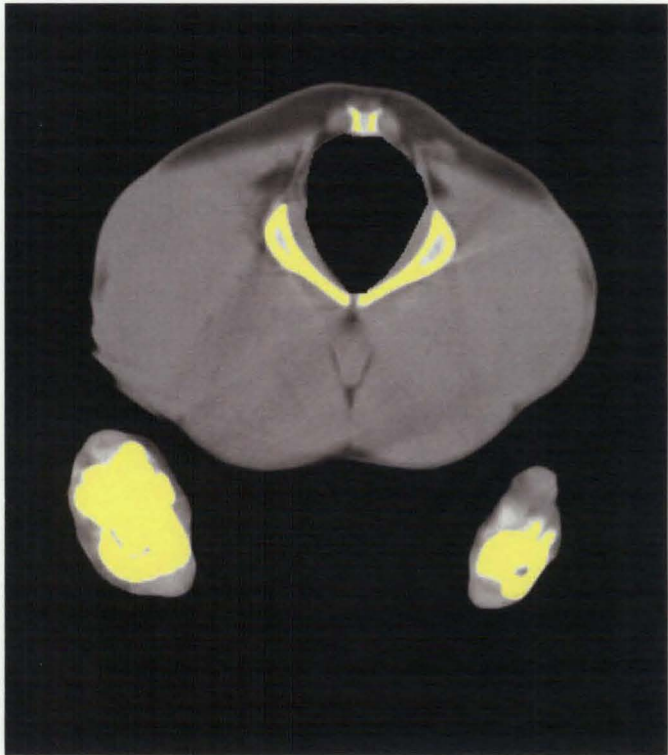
CT image of pixels at 255 grey scale corresponding to bone. A total of 11% of pixels are highlighted.
